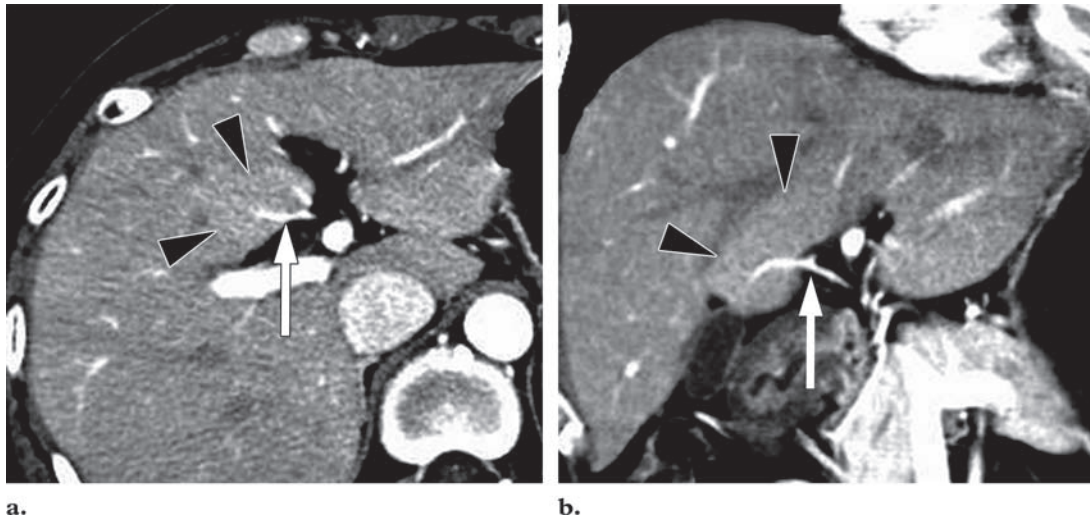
Pseudolesion in segment IV of the liver due to aberrant right gastric venous drainage in a 49-year-old woman. Arterial phase axial (a) and coronal reformatted (b) CT images show a focal enhancing area (arrowheads) in the posterior aspect of segment IV of the liver and inflow from an aberrant right gastric vein within the enhancing area (arrow).
